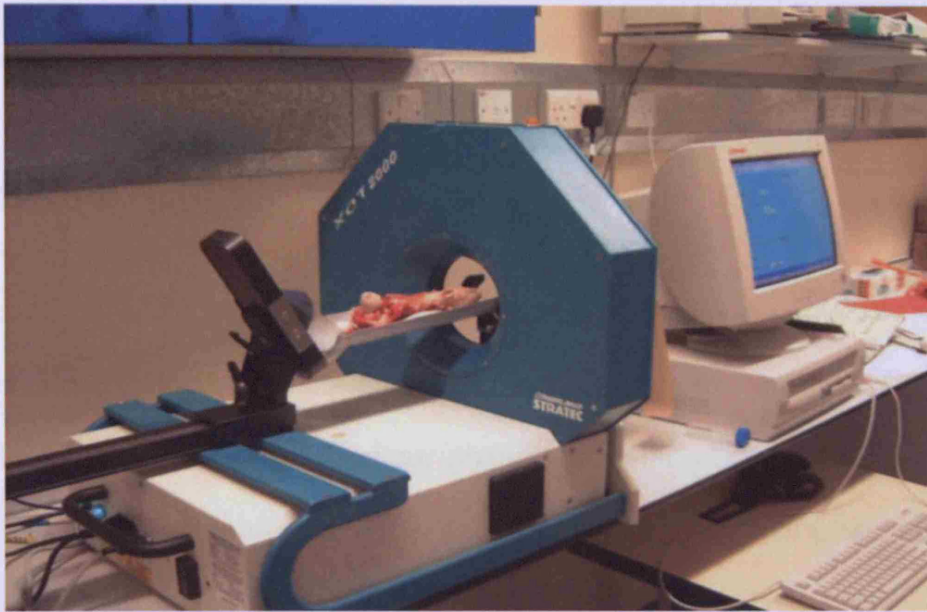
Computed tomography machine used to measure defect densitometry.
